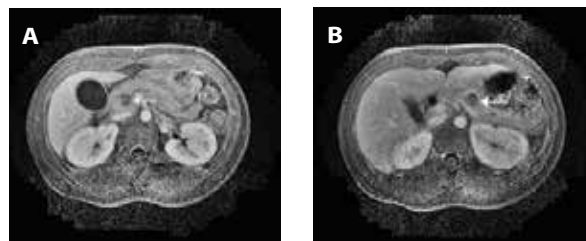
Multiaxial, multisequence abdominal magnetic resonance imaging with and without gadolinium revealing acute pancreatitis and 2 hypodense masses (both measuring 16 × 15 mm) within the head (A) and tail (B) of the pancreas.
